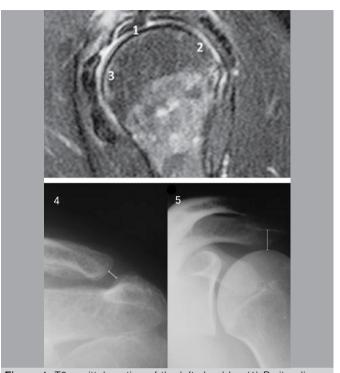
T2 sagittal section of the left shoulder. (1) Peritendinous hypersignal in the supraspinatus and liquid in the subacromial and subdeltoid bursa; (2) Infraspinatus ligament. X-ray of the left shoulder. Hypersignal of the rotator cuff, between the insertion of the supraspinatus; (3) and subscapular ligaments; (4) ACJ space: distance between the medial tip of the acromion and the lateral edge of the clavicle; (5) Acromio-umeral space. 5.6
